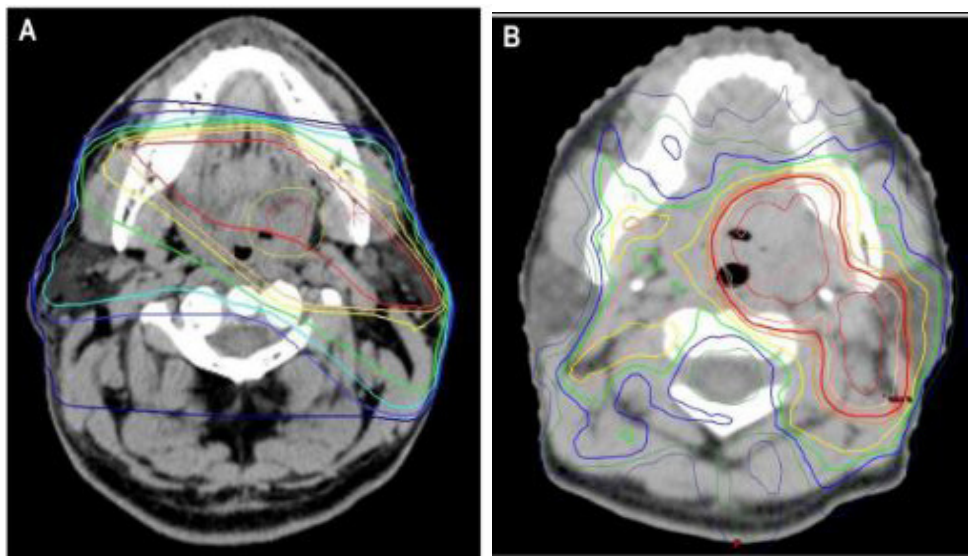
Planning computed tomographic images of three-dimensional conformal radiation therapy (A) and intensity-modulated radiation therapy (IMRT) (B). The right parotid gland is spared by IMRT (B).
